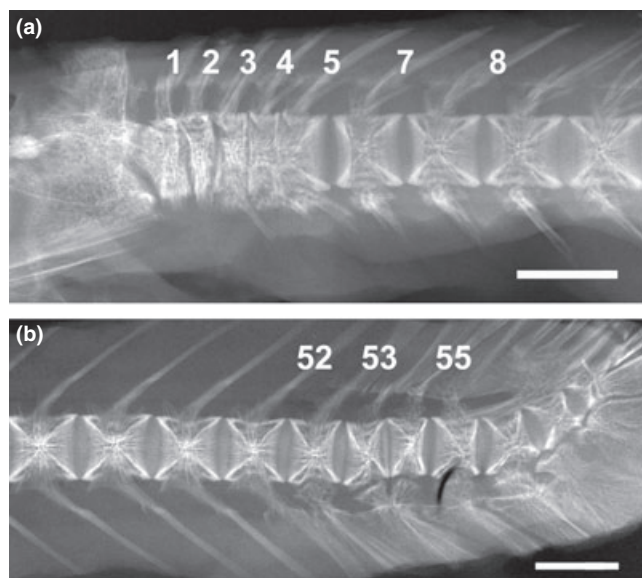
Lateral radiograph of deformed vertebral bodies taken at the end of the experiment in June 2007 from the cranial trunk (V1-8) (a) and tail fin (V50-58) (b) regions of the vertebral column. The vertebra number is indicated on the corresponding neural arches. Scale bar = 1 cm
